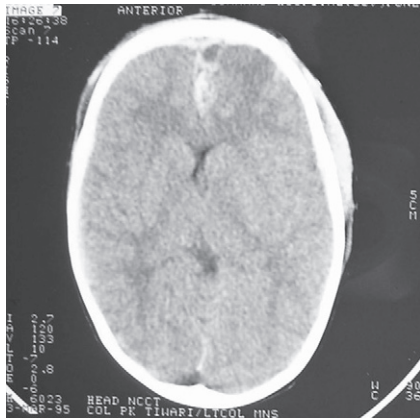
CT showing ISDH involving anterior falx and frontal pole
